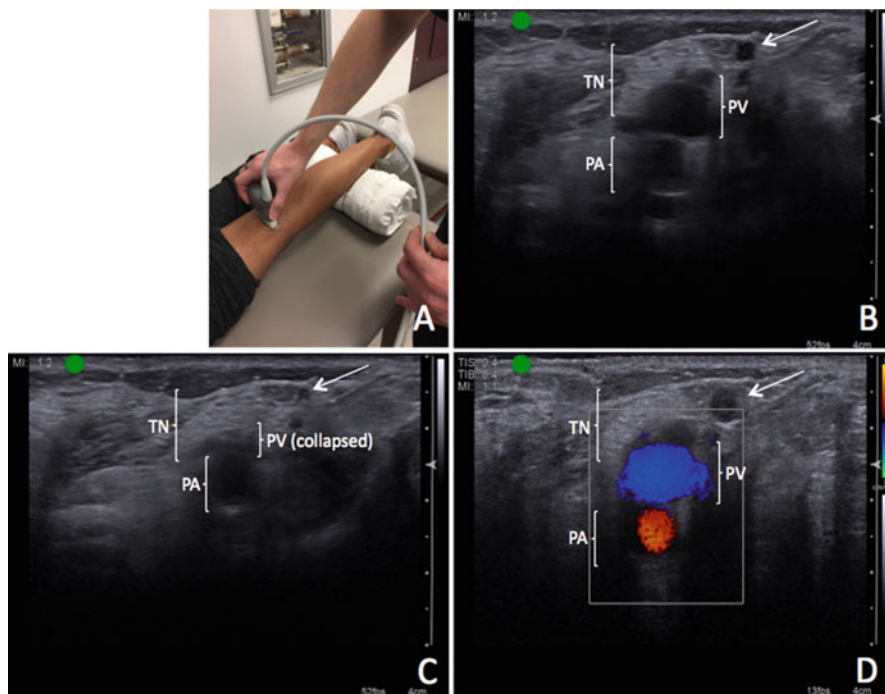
Identification of the popliteal vein and artery in the popliteal fossa and demonstration of coaptation in the popliteal vein. The position of the transducer used to acquire a transverse view of the popliteal fossa is shown in (a). The transducer marker is pointing laterally. The corresponding gray scale image is shown in (b). The popliteal vein (PV) and popliteal artery (PA) are indicated. The tibial nerve (TN) appears as a crescent-shaped, hyperechoic structure superficial to the popliteal vein. In (c) compression of the popliteal fossa with the transducer has collapsed the lumen of the popliteal vein. The opposing walls of the vein are touching each other (demonstrating coaptation) and the vein seems to disappear in the soft tissue. In (d) color flow Doppler is used to confirm identification of the uncompressed popliteal vein, shown in blue, and popliteal artery, shown in red. The arrows in (b–d) point to the same superficial vein, which like the deeper popliteal vein, collapses with compression by the transducer (shown in c)
